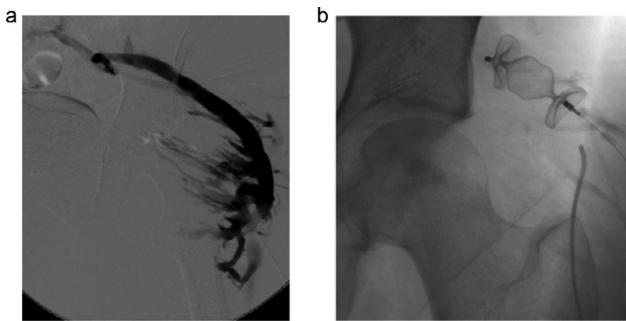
(a and b) (Same patient). Embolisation of dominant trans-gluteal vein with Amplatzer Vascular “Plug 2”. This was placed by percutaneous puncture using a Neff Percutaneous Access Set with ultrasound guidance after venography was completed.
